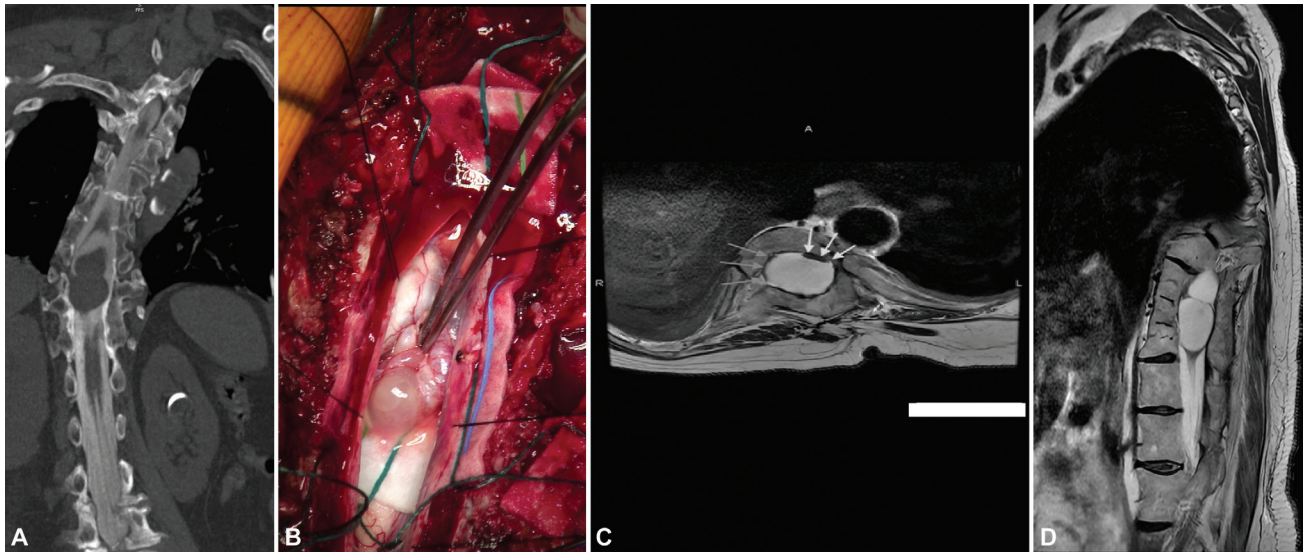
(A) Maximum intensity projection of coronal computed tomographic myelogram demonstrating diastematomyelia of the lower thoracic spinal cord as well as expansile intradural multiloculated cyst, likely intramedullary in origin arising from the right hemicord and does not fill with contrast. (B) Intraoperative picture of intramedullary cyst. (C) Axial T2 magnetic resonance imaging (MRI) demonstrating compression of the two spinal cords, with right (gray arrows) more compressed than left (white arrows). (D) Sagittal T2 MRI of the spine showing compression of the left hemicord by the cyst and causing syrinx.
